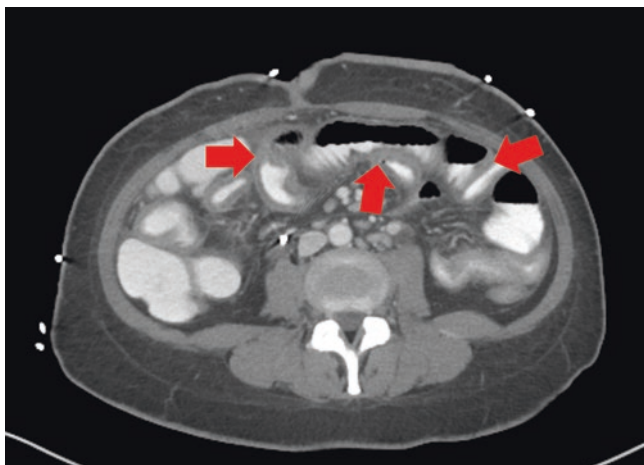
CT scan imaging of a cancer patient with neutropenic ileitis. A neutropenic leukemic patient presents with profuse diarrhea and minimal abdominal pain but no fever. The CT scan demonstrated significant thickening of the wall of ileum (arrows) consistent with ileitis
